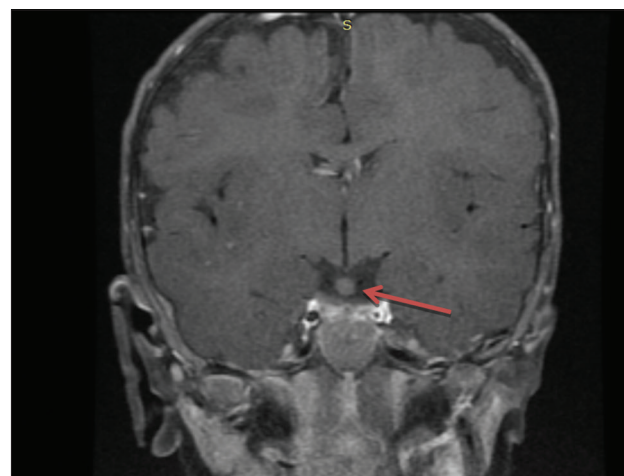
T1-weighted image post-contrast, coronal section showing hypothalamic hamartoma
